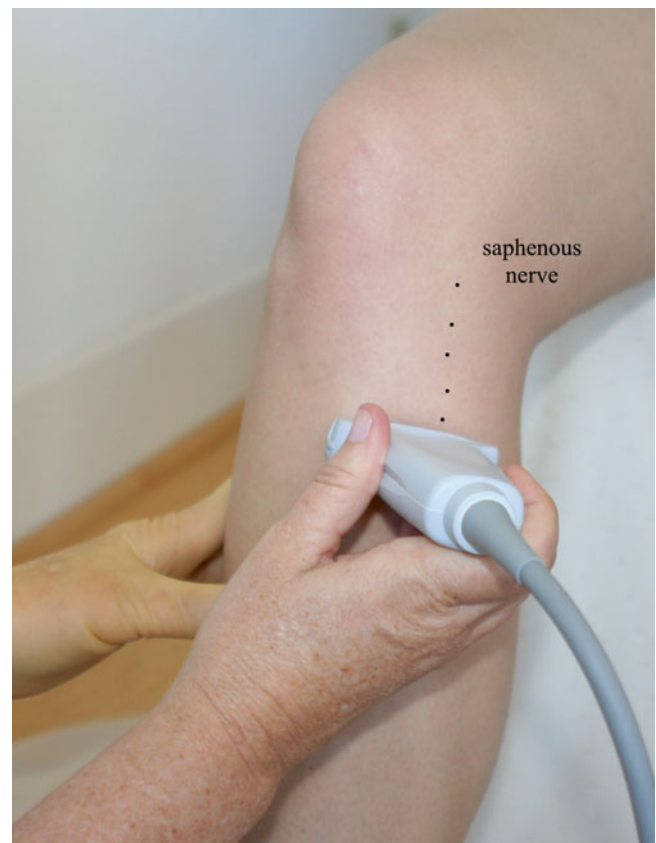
Cross-sectional (*short axis*) ultrasound probe placement (Image courtesy of Andrea Trescot, MD)
